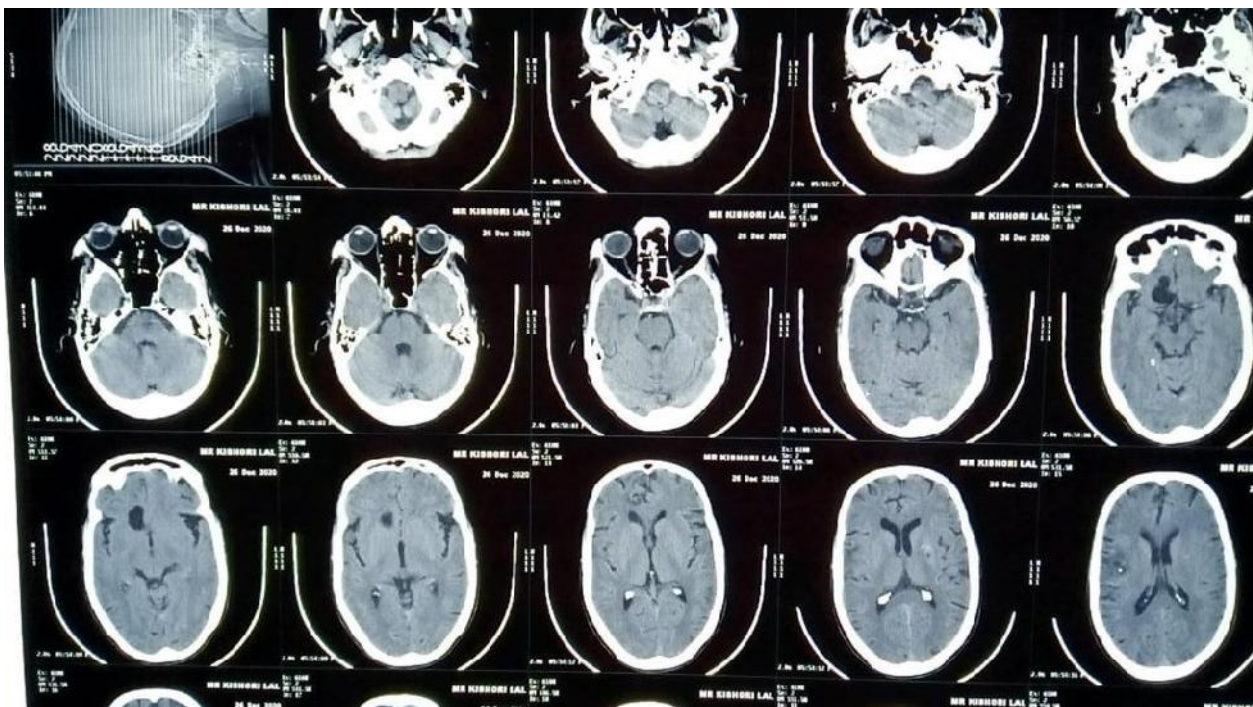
CT scan showing calcified lesion in frontal lobe of brain
